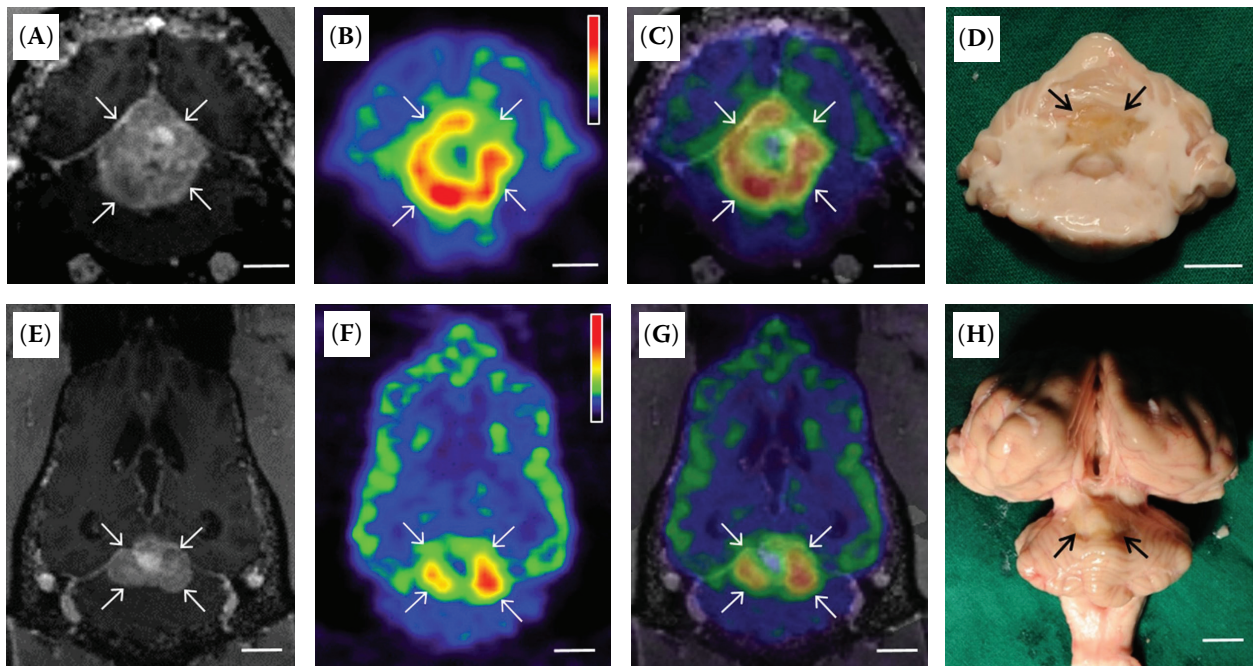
Characteristics of intracranial histiocytic sarcoma seen on 7 T-MRI/ $^{18}\text{F}$ -fluorodeoxyglucose-positron emission tomography and necropsy findings. Transverse (A–D) and dorsal (E–H) images of the brain are pictured. (A, E) On post-contrast T1-weighted image, an enhanced mass (arrows) was observed in the cerebellar vermis. (B, F)  $^{18}\text{F}$ -fluorodeoxyglucose-positron emission tomography images demonstrated an area of high  $^{18}\text{F}$ -fluorodeoxyglucose uptake with a reddish-to-yellowish colour (arrows) in the cerebellum. The colour bar expresses standardised uptake value [minimum (black): 0, maximum (red): 10]. (C, G) The anatomical location of the hypermetabolic area (arrows) was clearly identified by combining 7 T-MRI images with positron emission tomography images. (D, H) At necropsy, a nodular mass (arrows) was found in the cerebellar vermis. Scale bar 1 cm
